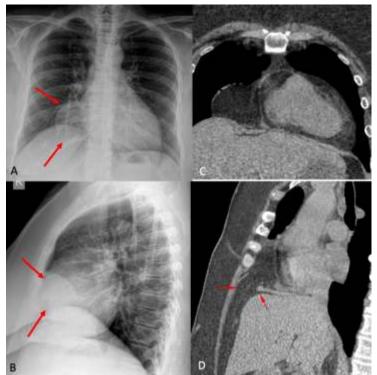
(A-D): Frontal (A) and lateral (B) chest radiographs show a medial cardiophrenic angle lesion, which is fat containing (arrows) on the coronal CT scan (C) and represents omentum herniated through a foramen of Morgagni defect (arrows in D).
